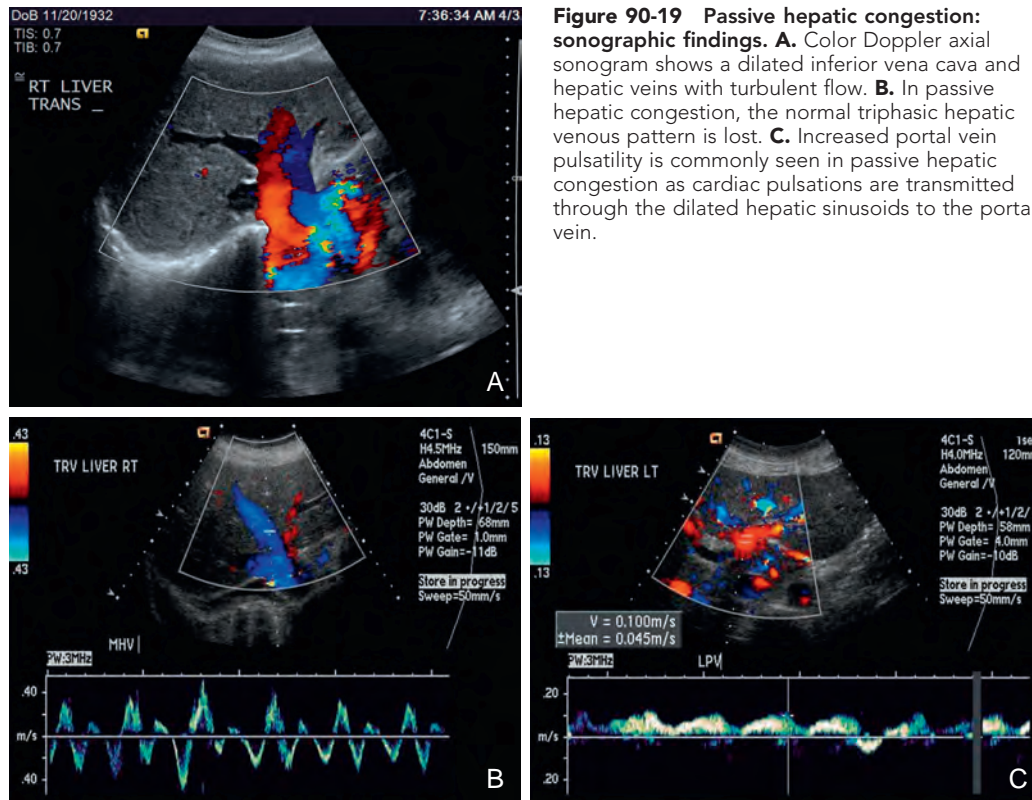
Passive hepatic congestion: sonographic findings. A. Color Doppler axial sonogram shows a dilated inferior vena cava and hepatic veins with turbulent flow. B. In passive hepatic congestion, the normal triphasic hepatic venous pattern is lost. C. Increased portal vein pulsatility is commonly seen in passive hepatic congestion as cardiac pulsations are transmitted through the dilated hepatic sinusoids to the portal vein.
